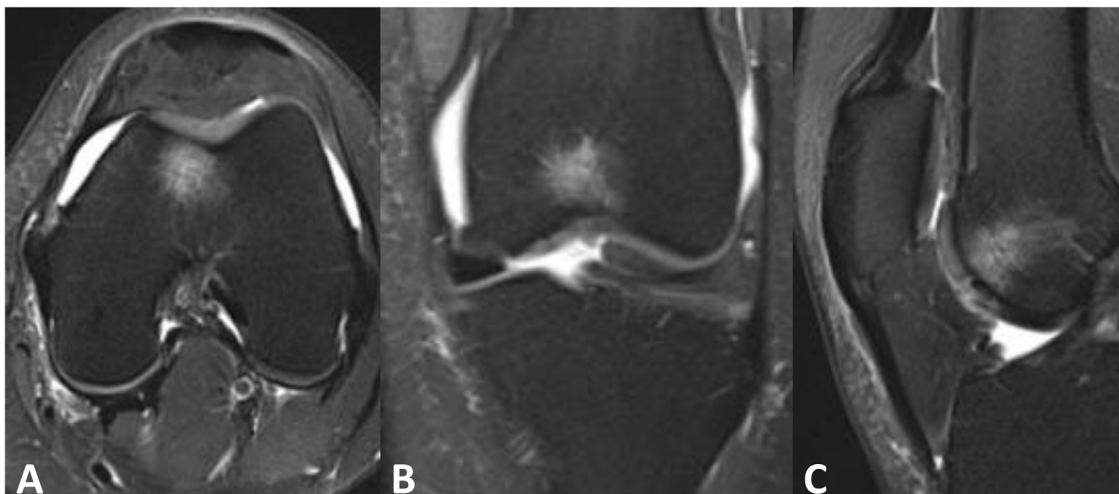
T2-weighted MRI with A) axial, B) coronal, and C) sagittal slices demonstrating a focal chondral defect of the medial femoral trochlea with underlying subchondral edema.
